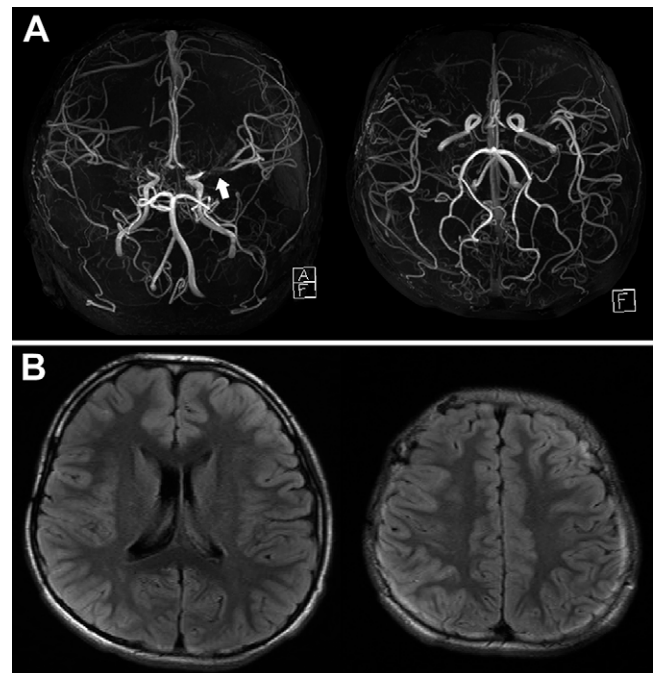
Approximately 2 years after the patient had surgery on the right side, transient weakness of the right side of his face and upper limbs began to reappear frequently. A: MRA shows progression of stenosis of the left ICA terminal without PCA involvement (*white arrow*). B: No new cerebral ischemic lesions were found on FLAIR.
